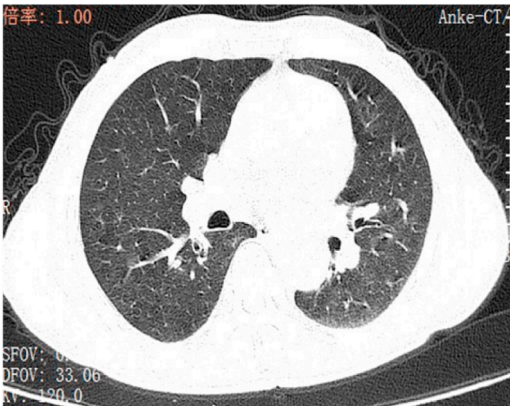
Chest high-resolution CT images at follow-up. The exudate foci in the lungs are basically absorbed and disappear.
